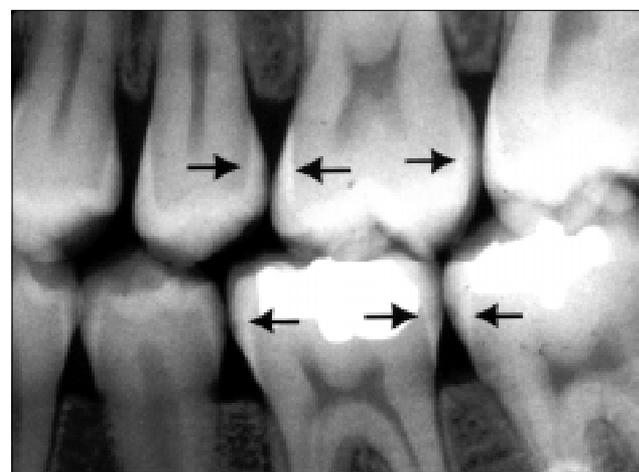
Case 3: 13 year, 6-month-old male. Left bitewing radiograph.
